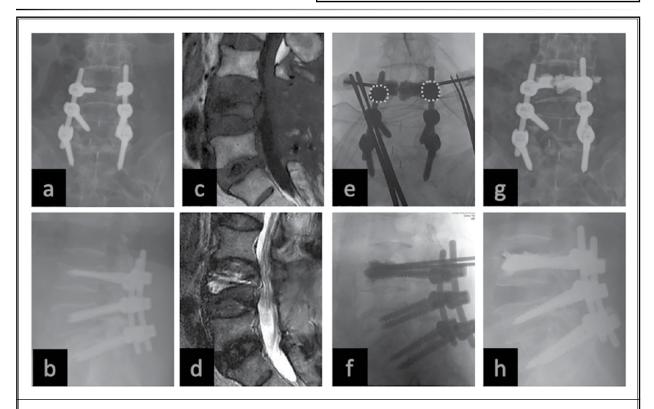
(a, b) Preoperative plain films show an instrumented vertebral fracture at L4 with a decrease in vertebral body height. (c, d) Preoperative sagittal T1-weighted and T2-weighted images showing the intervertebral cleft sign with air and fluid in parallel with the instrumented fracture at L4. (e, f) Intraoperative anteroposterior and lateral images showing good cement augmentation via a lateropedicular approach. The ideal trochar insertion was identified as 2 o'clock or 10 o'clock lateral to the dotted screw head in anteroposterior view. (g, h) Plain films obtained immediately after surgery showing good cement filling within the L4 vertebral body. Note the small round density around the L4 upper endplate. This was the extravasated cement after removal of the 12.7cm trochar; the patient did not have any postoperative cement-induced neurological deterioration or complication.
